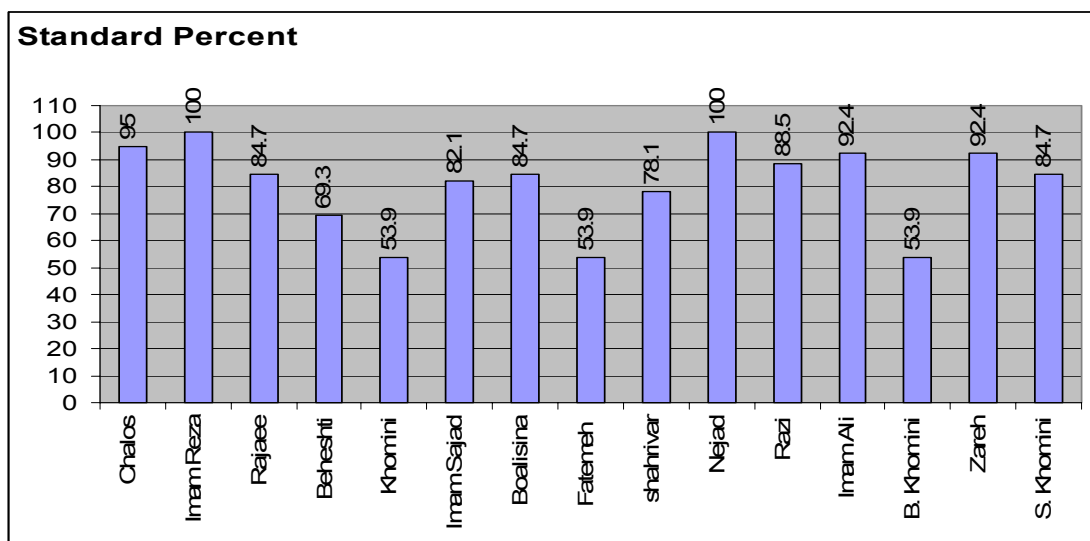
condition of radiography instruments considering the parameter under study
